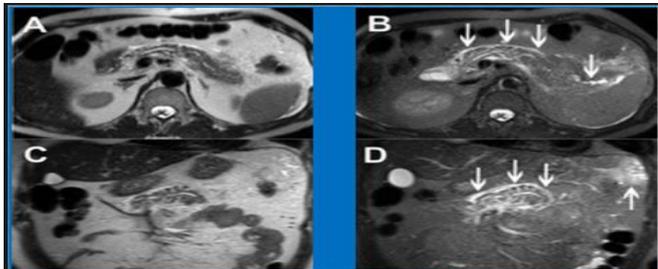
Normal MRI images of Pancreas
